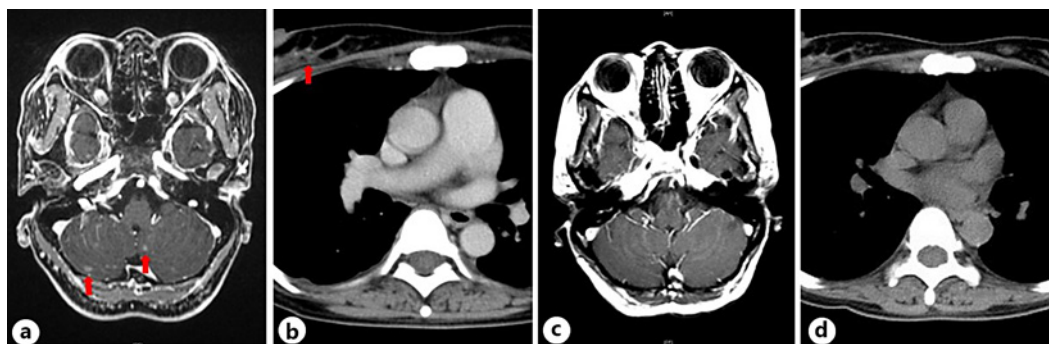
CT and MRI before and after T-DXd treatment. a T1-weighted MRI of the head showed multiple high-signal nodules in the cerebellum, and a diagnosis of cerebellar metastasis was made (red arrows). b On CT, the primary lesion in the right mammary gland had shrunk compared to the size at the initial treatment (red arrow). c Contrast-enhanced MRI after the second course of T-DXd shows that the intensely nodular areas in the cerebellum have shrunk and are difficult to identify. d On CT, the primary right breast cancer site showed no change in size. CT, computed tomography; MRI, magnetic resonance imaging; T-DXd, trastuzumab deruxtecan.
